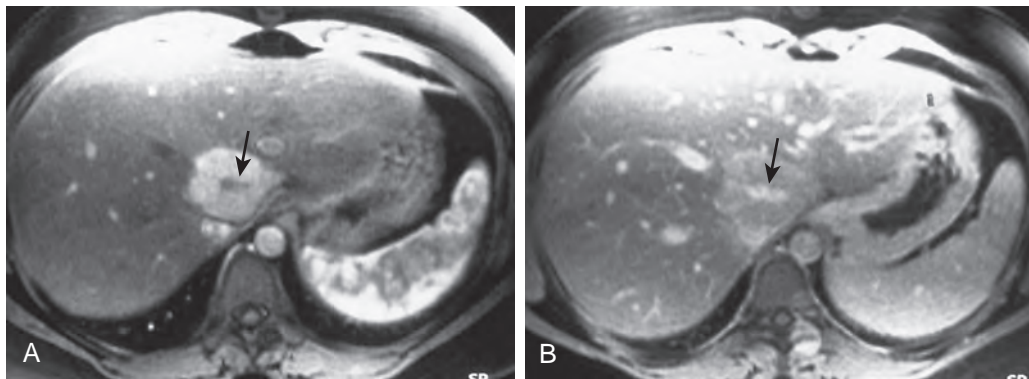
Focal nodular hyperplasia: MRI features. A. During the arterial phase of enhancement, the lesion shows robust enhancement with the exception of the central scar (arrow). B. The mass rapidly de-enhances, and there is enhancement of the central scar (arrow).
